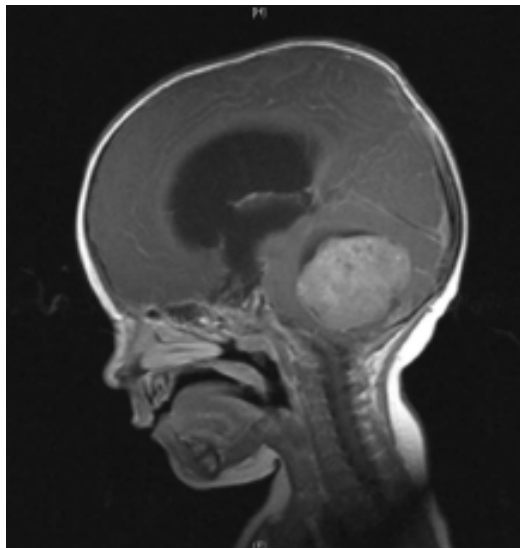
MRI image of head showing medulloblastoma (*Desouza et.al, Frontiers in Oncology, 2014*)
